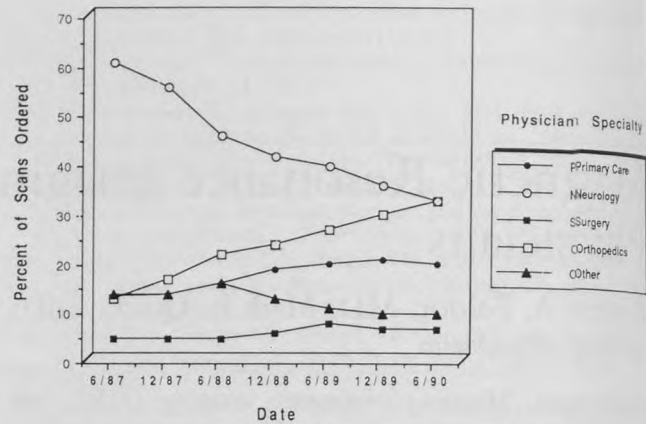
Percentage of total MRI scans ordered by physicians over a 3-year period.
